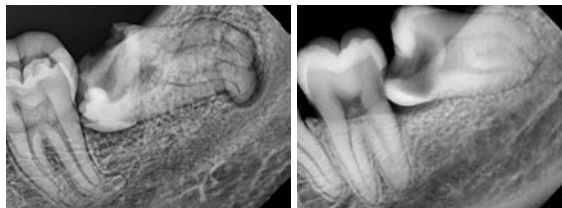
The intraoral radiographs show a carious impacted tooth. During its sectioning and luxation, it is likely to be fragmented. Before suturing, the surgical site should be carefully inspected to identify and remove any tooth fragments.
